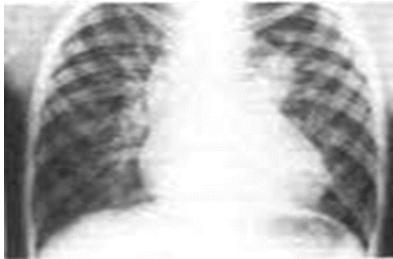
X-ray of the chest.
